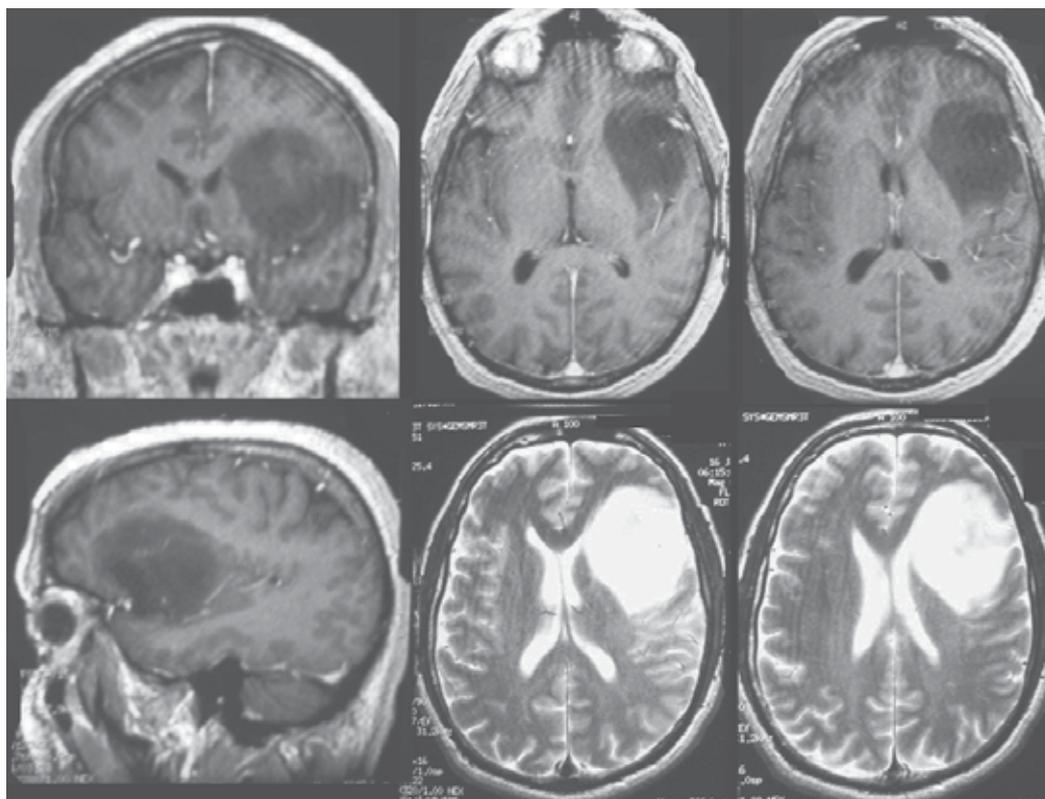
Preoperative gadolinium enhanced T1- and T2-weighted MRI of a LGG infiltrating, left insular region, frontal and temporal operculum and fronto-orbital and temporopolar areas (5A of Yasargil classification). The tumour extends above the superior insular sulcus into the corona radiata.
